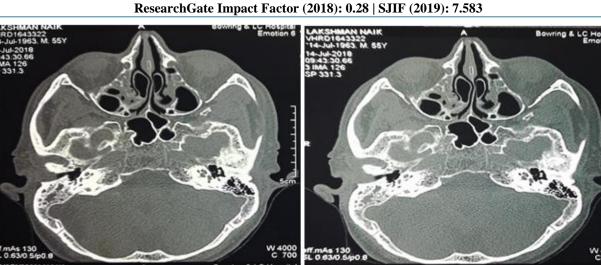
HRCT Temporal Bone
